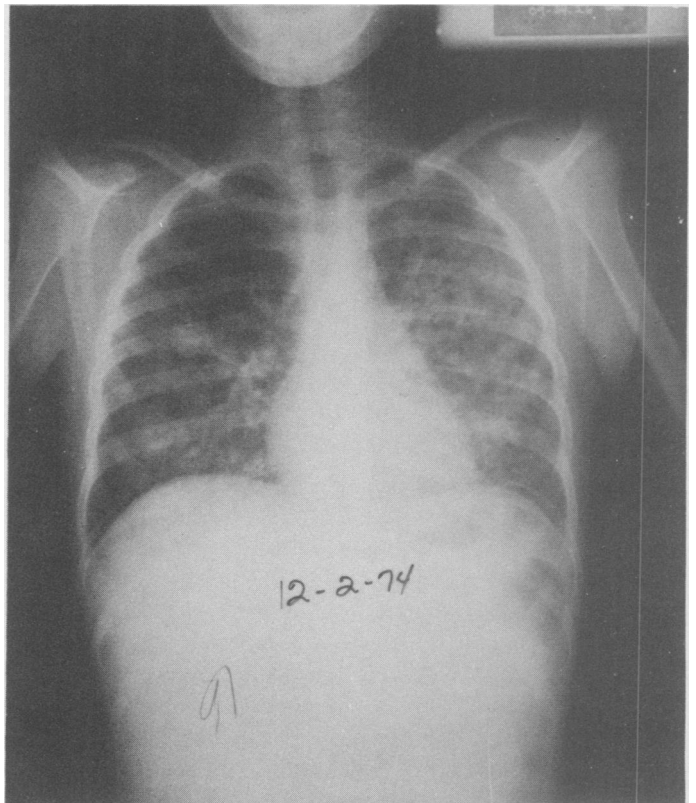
Chest x-ray in patient 7 following the onset of dyspnea and fever. In spite of continued heavy growth of *Aspergillus* in the sputum, open lung biopsy was performed which demonstrated *Pneumocystis carinii*.
